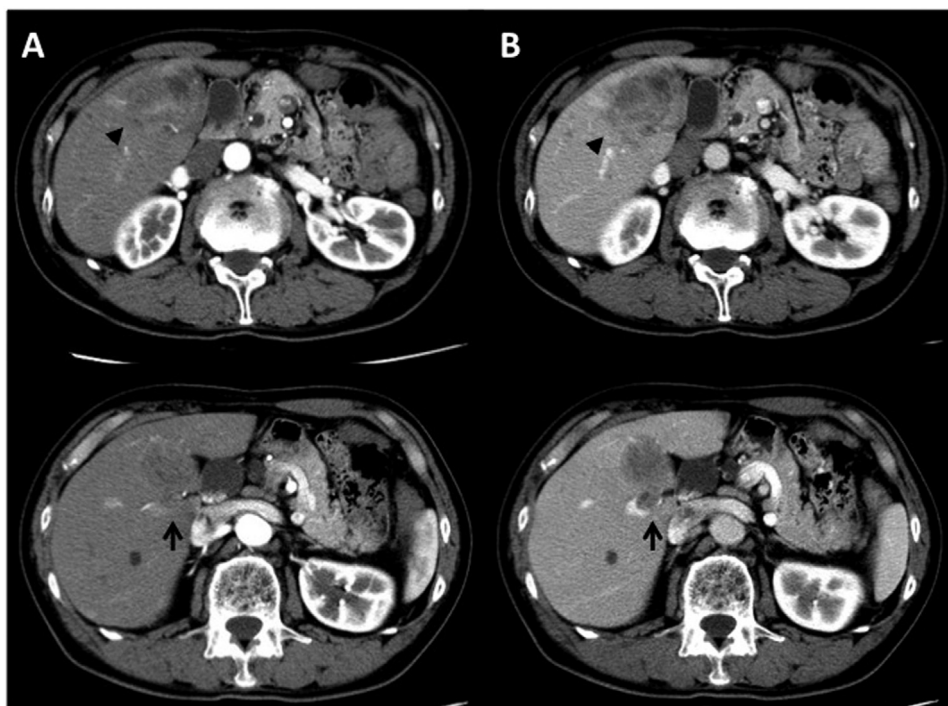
Contrast-enhanced computed tomography (CECT) scan for initial diagnosis. The image shows a tumor 53 mm in size (arrowhead) and portal vein tumor thrombosis (PVTT) in the posterior branch of the portal vein (arrow). The tumor and suspected PVTT are slightly enhanced during the early-phase CECT (A) and are washed out during the equilibrium phase (B).
